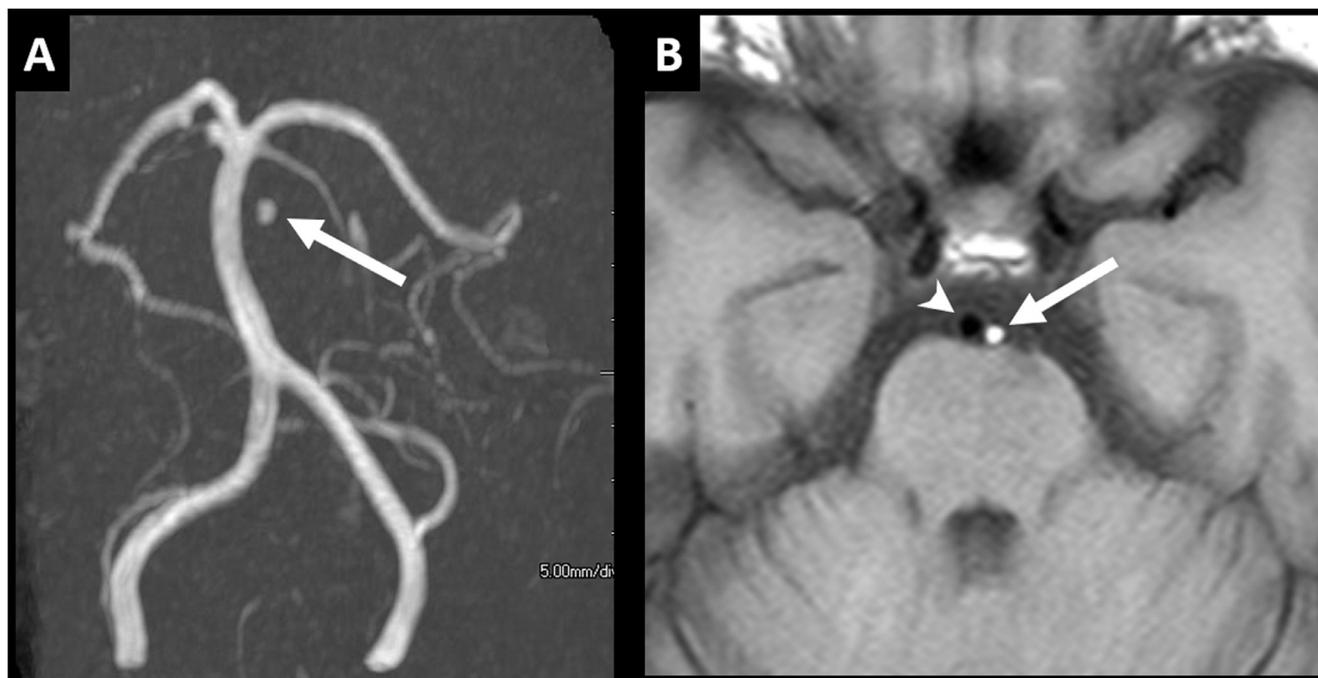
Follow-up MRI at about 1 year later. Magnetic resonance angiography (A) revealed the presence of a high-intensity spot close to the basilar artery (arrow). Pre-contrast T1-weighted imaging (B) revealed the presence of a hyperintense nodular lesion (arrow) close to the basilar artery (arrowhead), indicating that the lesion was a basilar perforator aneurysm that still remained thrombosed.
